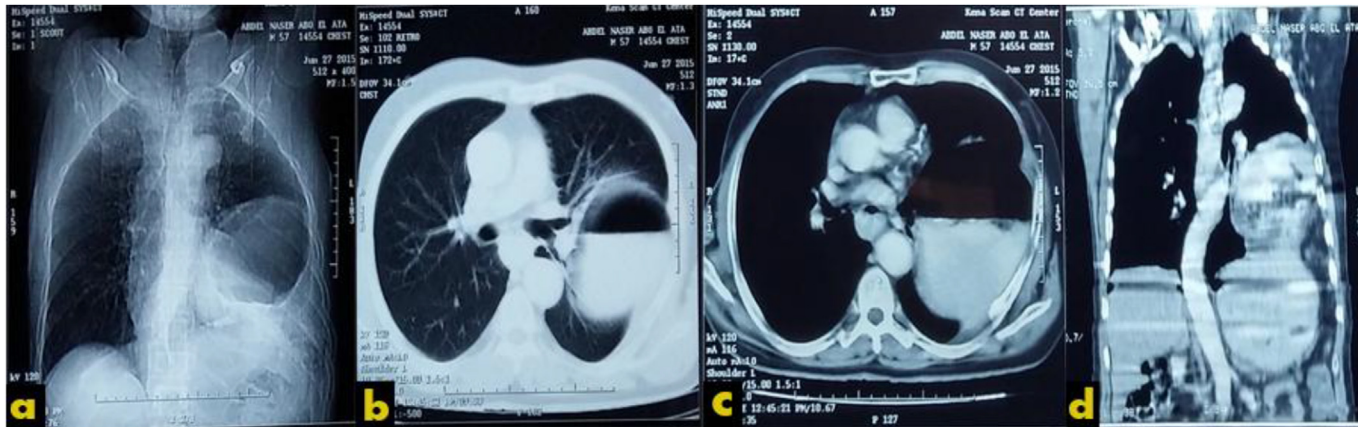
CT Chest of left diaphragmatic hernia. a: Showing chronic TDH with gastric content in the left hemithorax. b: Pulmonary window showing air fluid level. c: Mediastinal window of cross sectional view showing gastric content in the left hemithorax. d: Coronal view.
